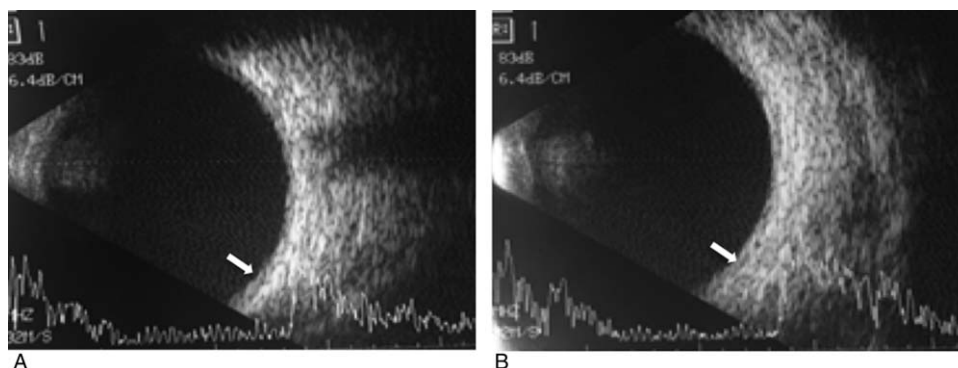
B-scan ultrasound images acquired on day 4 show resolution of the choroidal effusions (white arrows) in the right (A) and left (B) eyes.
